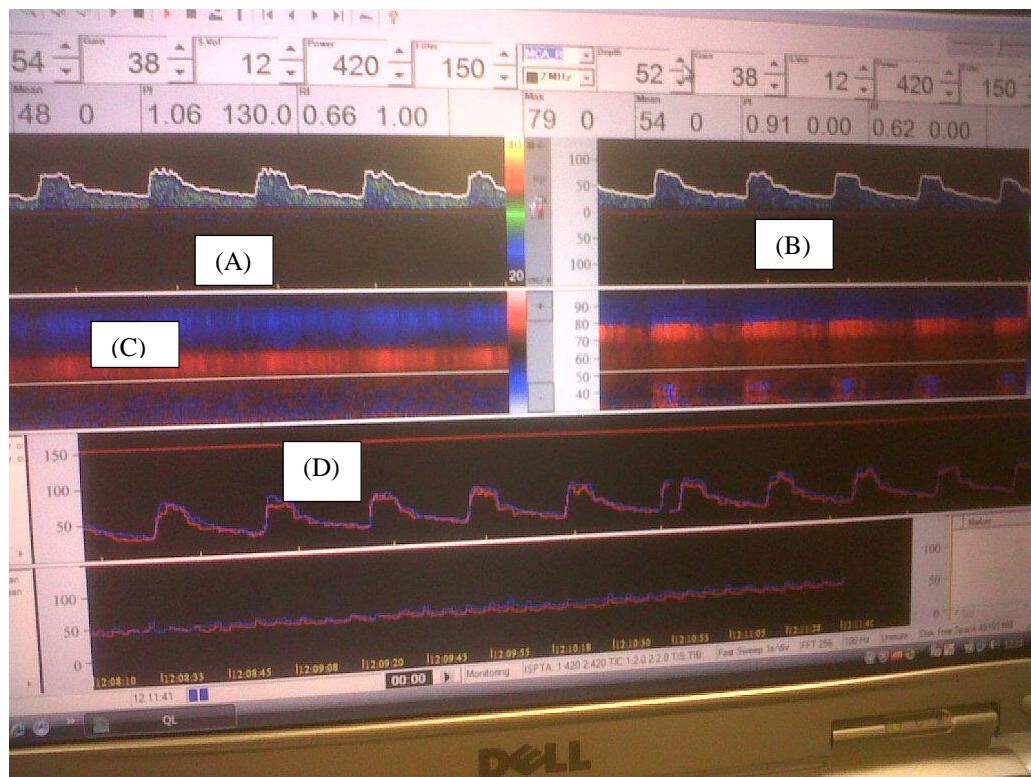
Doppler signal showing CBFV from Left MCA (A) and Right MCA (B). Doppler signal (C) towards probe (red) and signal away from probe (blue). Left and right CBFV superimposed on each other in real time recording (D).
